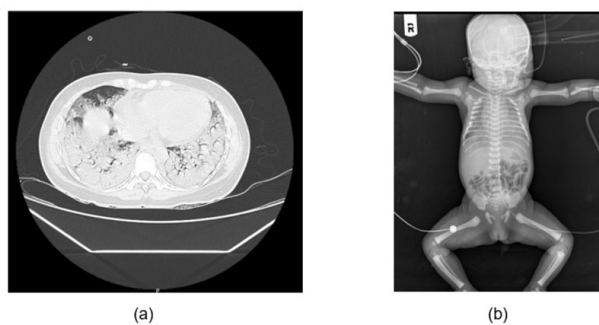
26-year-old pregnant woman with gestational age of 38 weeks presented with fever, dry cough and malaise underwent CT scan examination. (a) Coronal chest CT image of mother obtained just before delivery shows bilateral extensive ground-glass opacities (GGOs) with crazy wave pattern in both lungs. (b) Chest X-ray image at birth of the vaginally delivered baby girl (APGAR score of 3 & 4 at 1st min and 5th min respectively.) shows white-out lung, a complication due to maternal respiratory distress during labor
